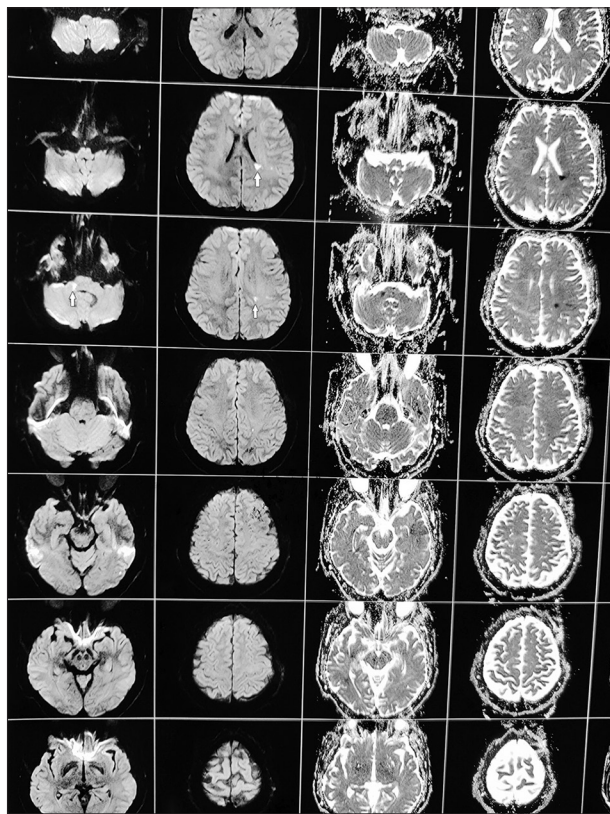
MRI reveals small focus area of restricted diffusion with corresponding ADC drop on right brachium pontis and left parietal periventricular white matter
